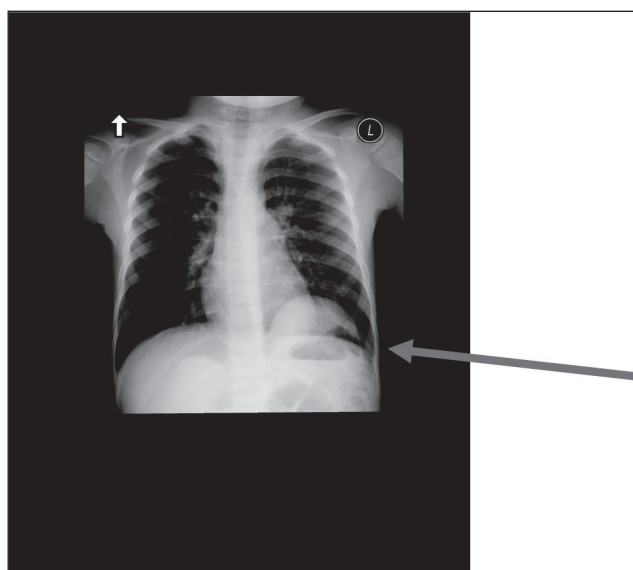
X-ray of the chest in patient with intrathoracic ectopic kidney.
